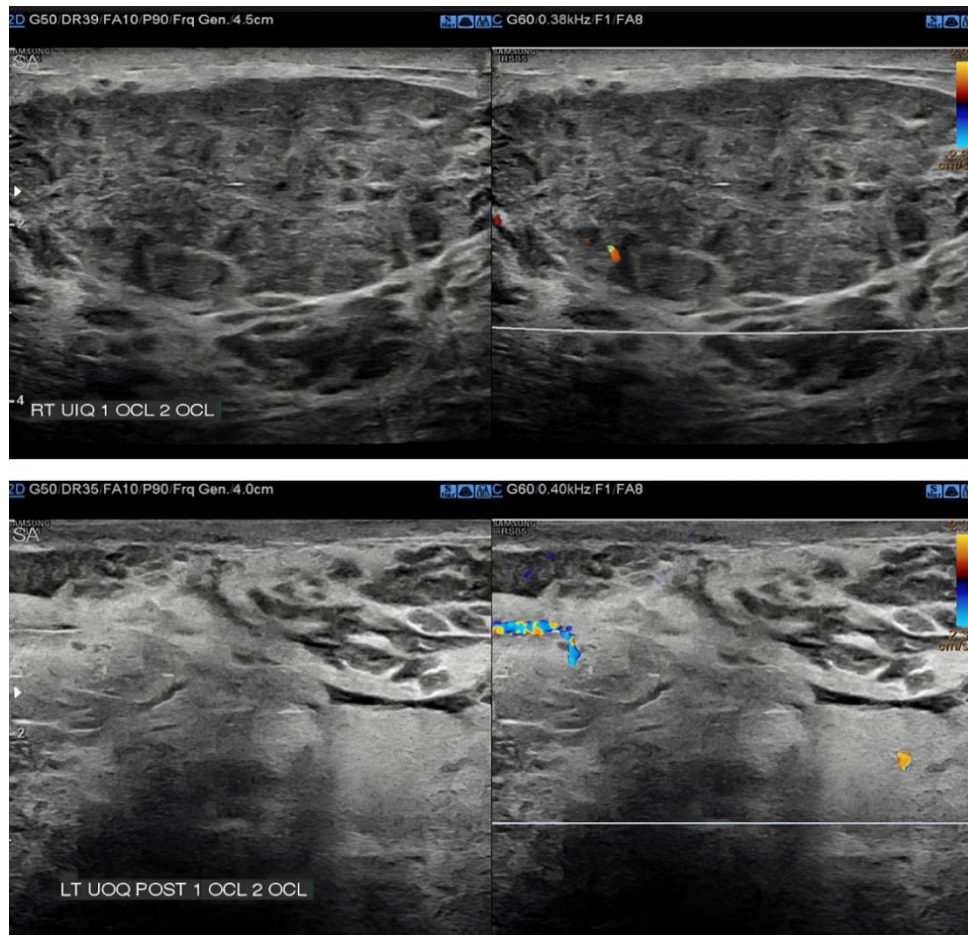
Selected grey scale and color doppler images both breasts (reprinted with permission of the patient)
